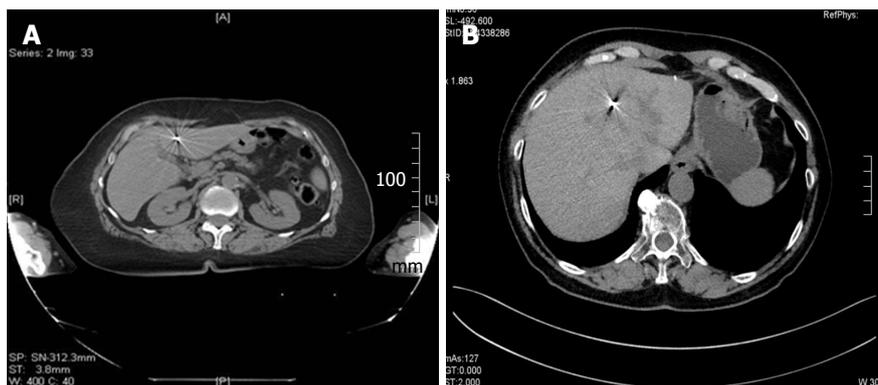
Well visualized fiducial markers. A: CT displaying of Grain cylindrical gold marker, 1 mm × 4 mm. This marker exhibits good contrast on X-ray images with typical "star effects"; B: CT displaying types of flexible wire notched gold marker, 0.28 mm × 10 mm, Gold Anchor marker. This marker exhibits good contrast on X-ray images demonstrating less artifacts. CT: Computed tomography.
